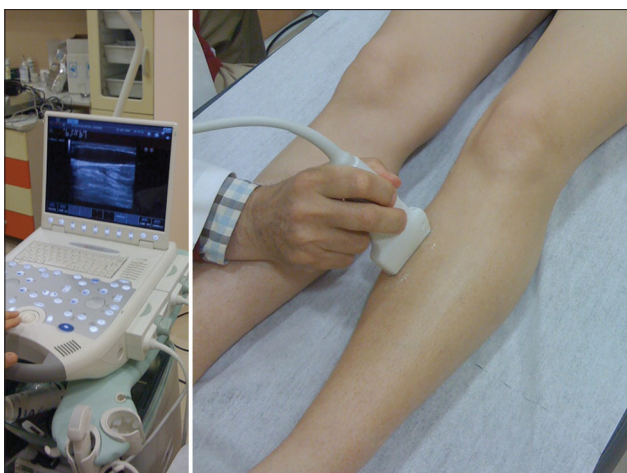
Ultrasound examination of tissues and vessels
